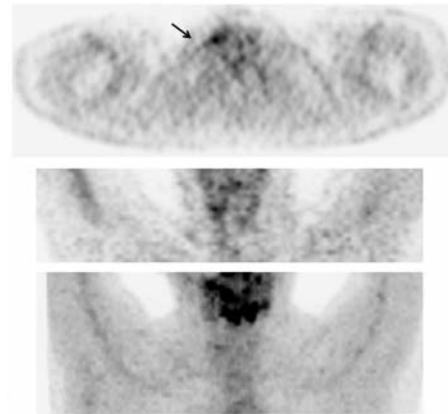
FDG-PET scan before Ptx/Cb CRT (only neck area shown): The malignant metastatic deposit in the right subglottic area (black arrow) was highly metabolically active and seemed to partially extend both medially and rostrally beyond its ill-defined borders, as suggested by the anatomical studies.
